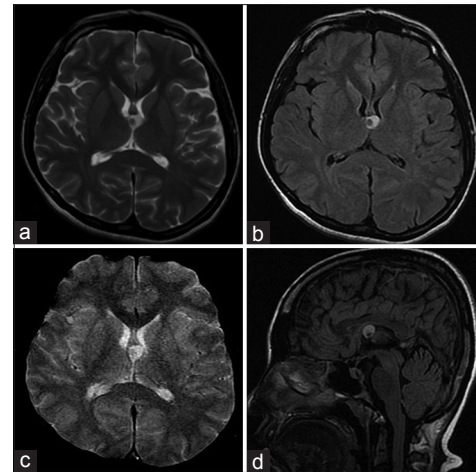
(a) T2-weighted axial magnetic resonance imaging and (b) axial fluid-attenuated inversion recovery images showing a 11 mm anterior third ventricular colloid cyst with mixed signal intensity, predominantly high signal but with a low-signal intracystic nidus. (c) T2*-weighted gradient images show no susceptibility (“blooming”) effects, thereby excluding the possibility of calcium or blood. (d) T1-weighted sagittal images showing a primarily hyperintense cyst with a hypointensity within it
